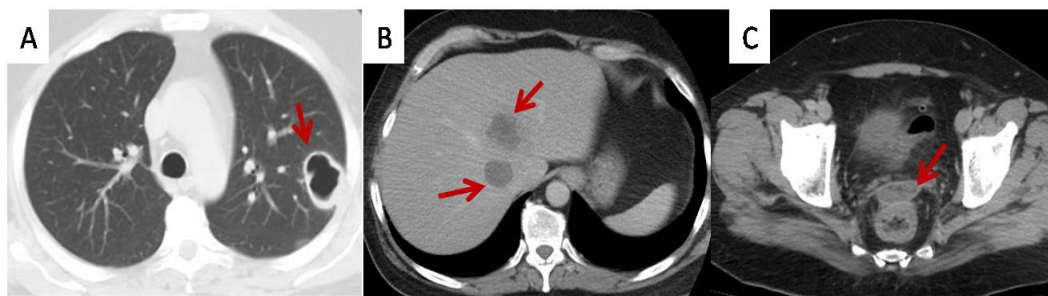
Before treatment on CT scan; A: Thorax CT scan: The lesion (lung abscess) is 43 x 30 mm in size before treatment. B: Upper Abdominal CT scan: Multiple liver abscesses in liver. C: Lower Abdominal CT scan: Sigmoid colon's abscess.
